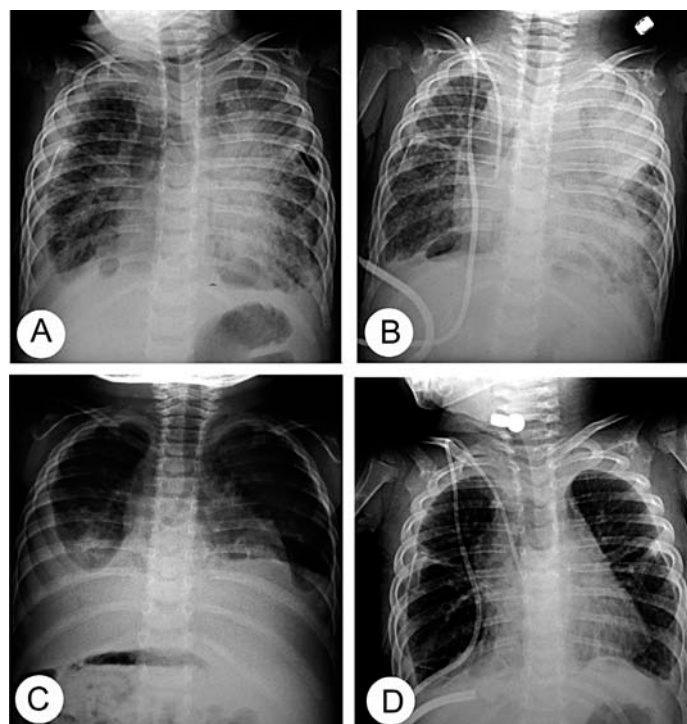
Pulmonary Lymphangiectasia. Chest radiographs, AP views.
